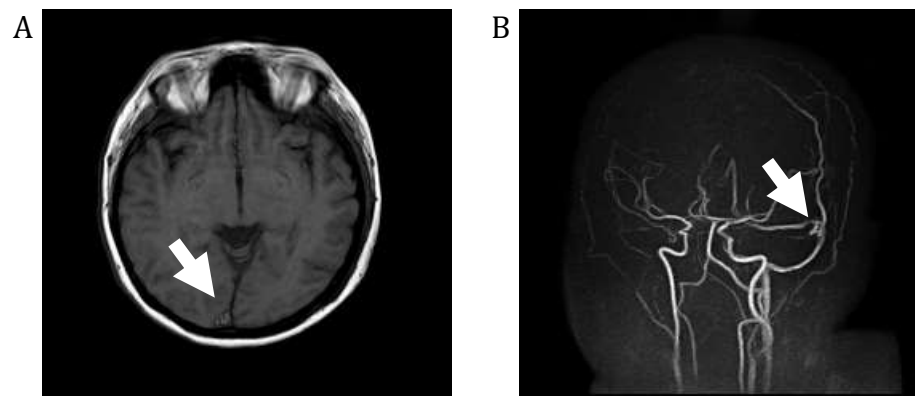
Non-Contrast Head MRI and MRA
